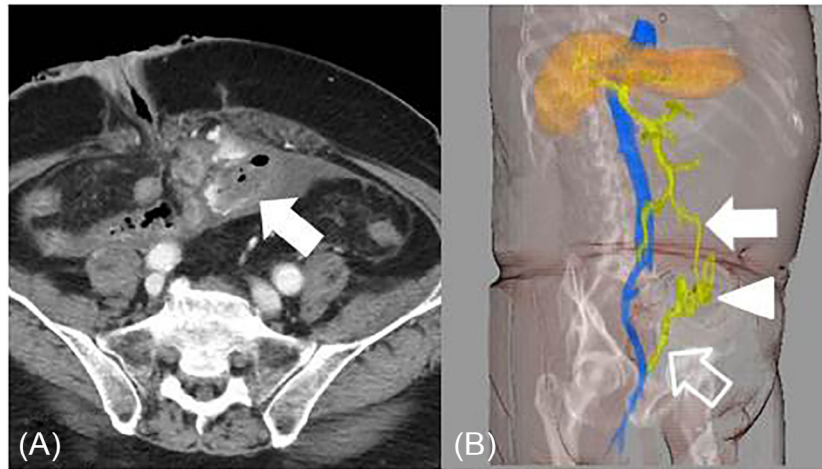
(A) Contrast-enhanced computed tomography scan reveals small intestinal varices and extravasation (arrow). (B) Three-dimensional computed tomography scan waving toward the right anterior oblique position reveals small intestinal varices (arrowhead), as well as the branch vessel of the superior mesenteric vein (arrow) and the right inferior epigastric vein (open arrow).
